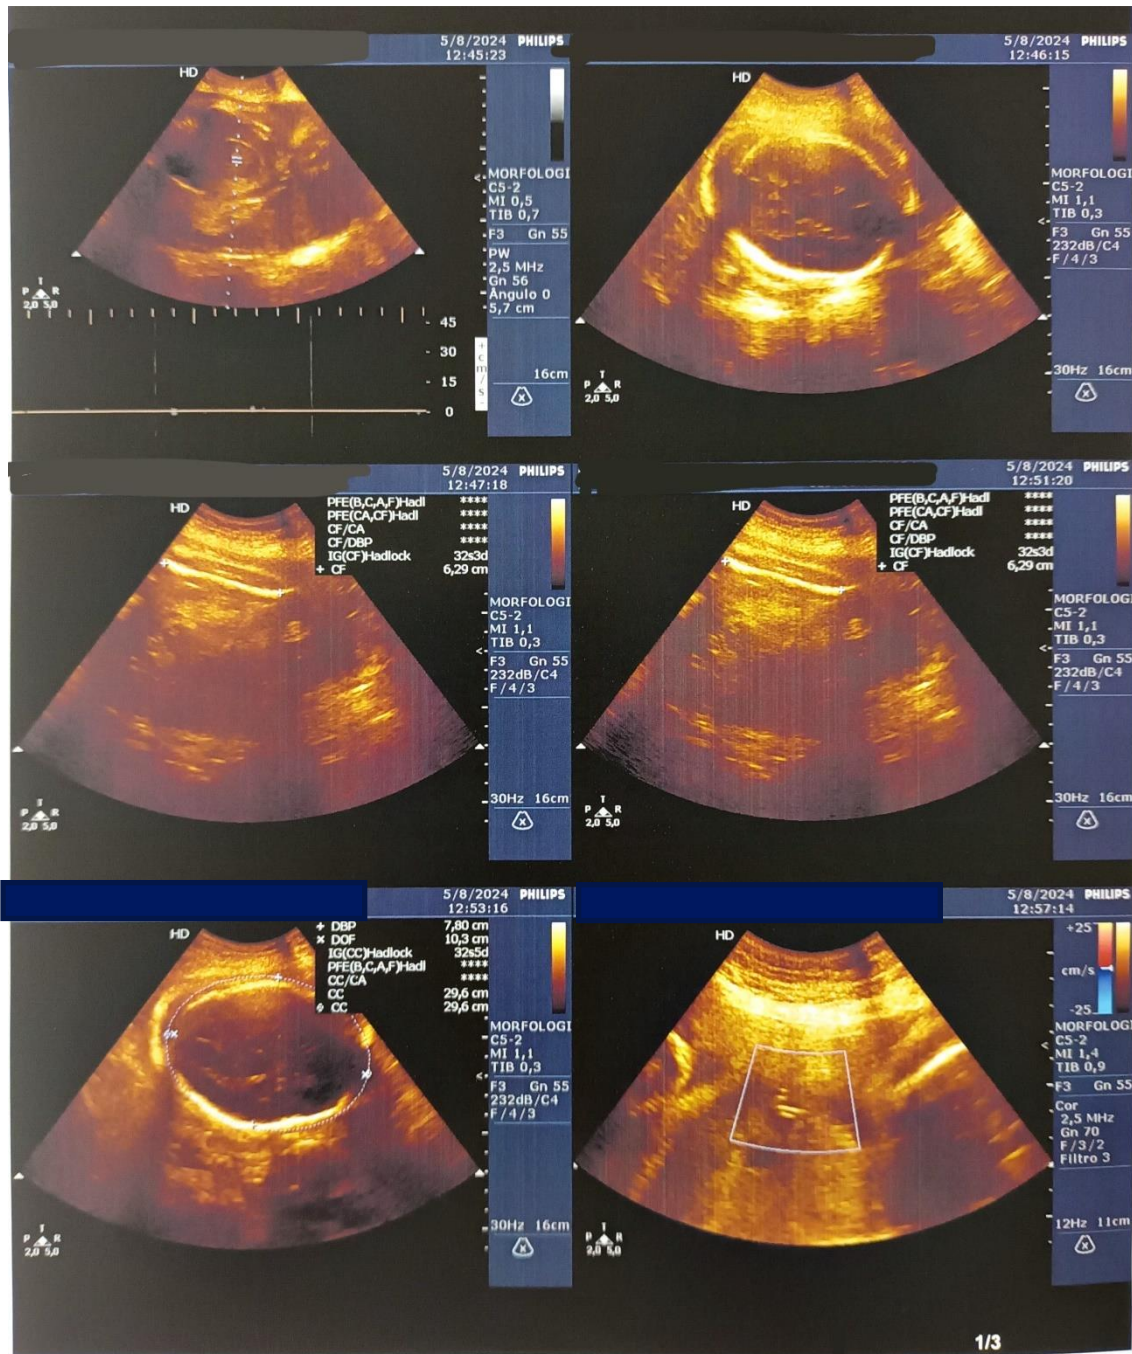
Ultrasound image taken on August 5, 2024, at 33 weeks and 1 day of gestation. The scan confirmed the absence of Fetal Heart Rate (FHR) and Spontaneous Fetal Movements, indicating fetal demise.
